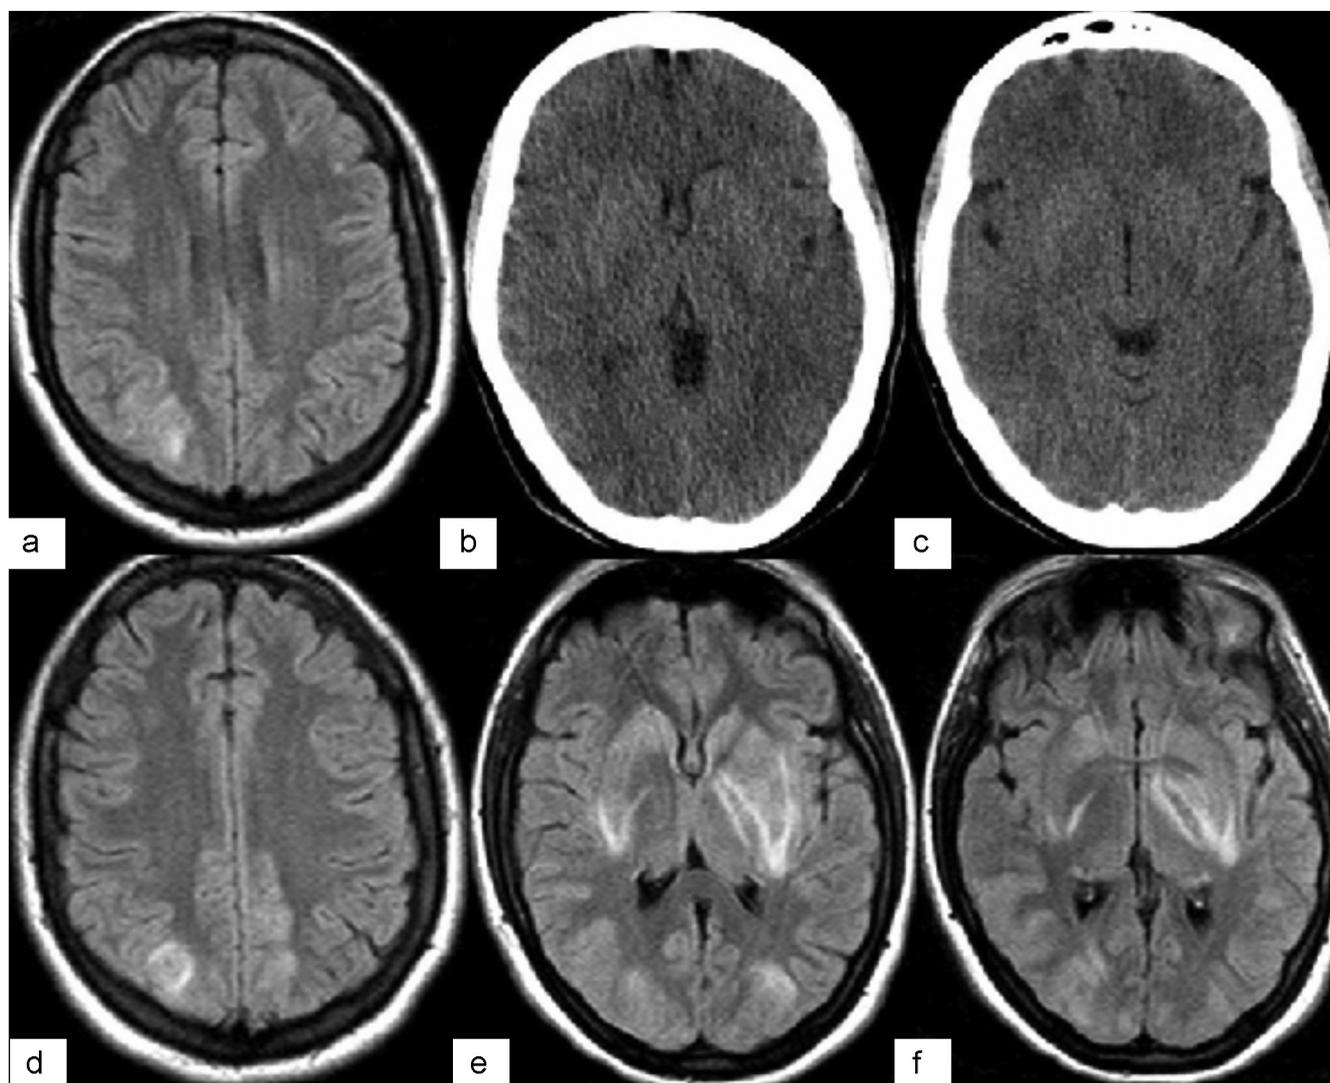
Axial CT (b) and (c) and MR (a) (d)–(f) images on the 3rd day of admission, with the patients full clinical recovery imaging abnormalities partially regressed.
